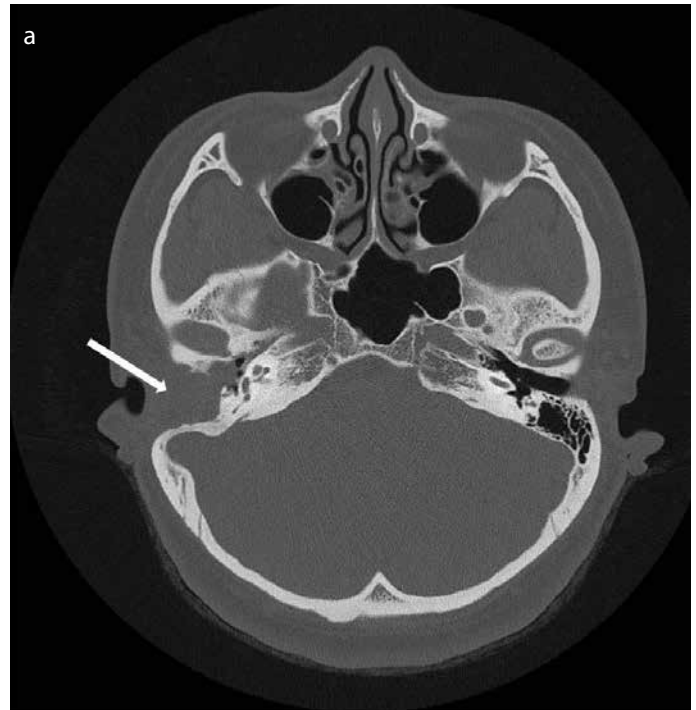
a, b. CT images show haziness, which occupies the external auditory canal and mastoid cavity (arrow), without a mass in the paranasal cavities. Axial view of temporal CT (A); coronal view of temporal CT. (B).
